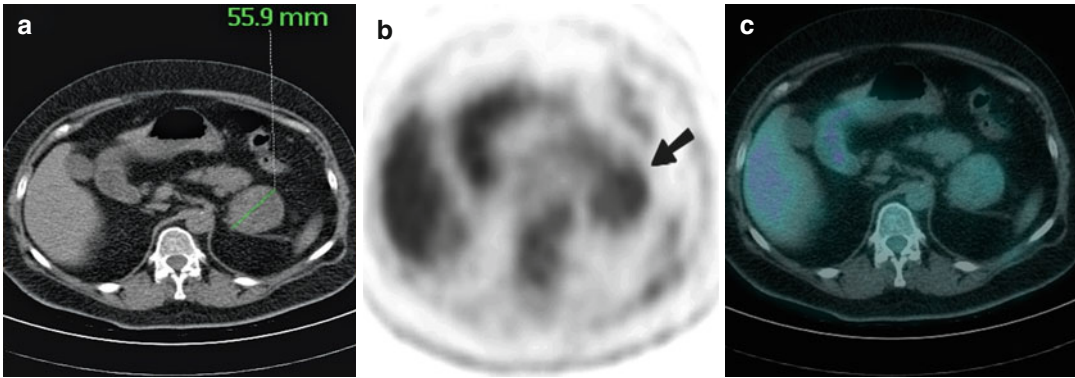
Transaxial CT (a), FDG PET (b) and combined PET-CT (c) images of a 53-year-old woman with no history of malignancy who presented with a 55.9 mm left adrenal mass. At the site of the mass on CT, there was mild heterogeneous FDG uptake on PET
